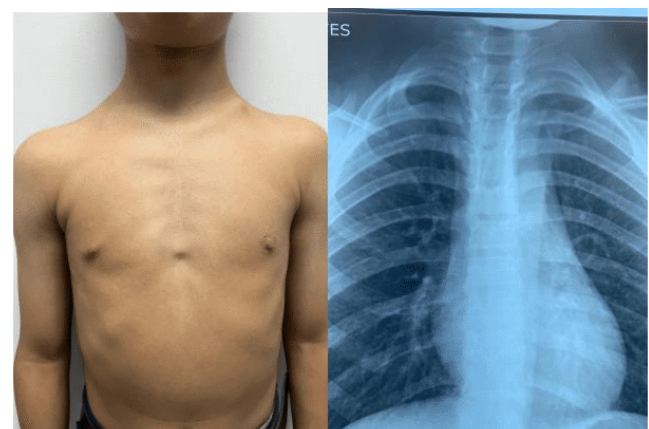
Frontal photograph depicting the triangular torso and posteroanterior (PA) chest radiograph showing a triangular shape of the thoracic cage and partial development of the clavicles.
